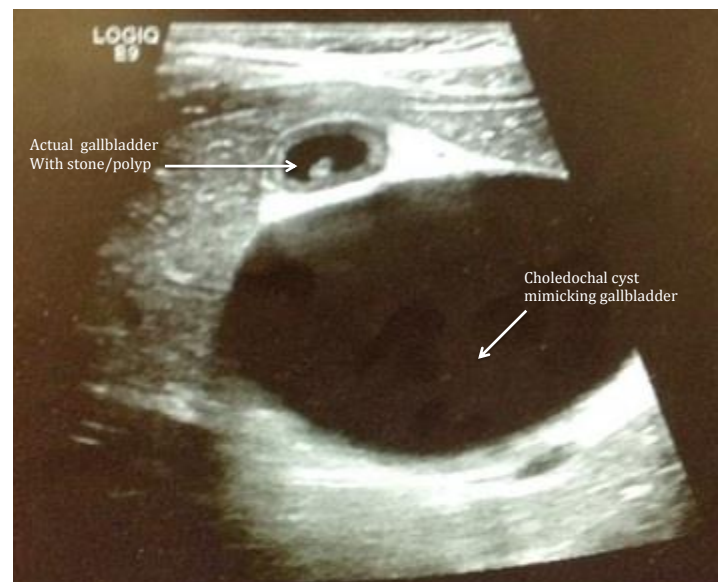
Follow-up radiologic ultrasound showing presence of mild intrahepatic biliary ductal dilatation as well as a large cystic mass with internal echoes and debris confirmed as a choledochal cyst. The gallbladder with multiple gallbladder stones or polyps is also pictured above.
